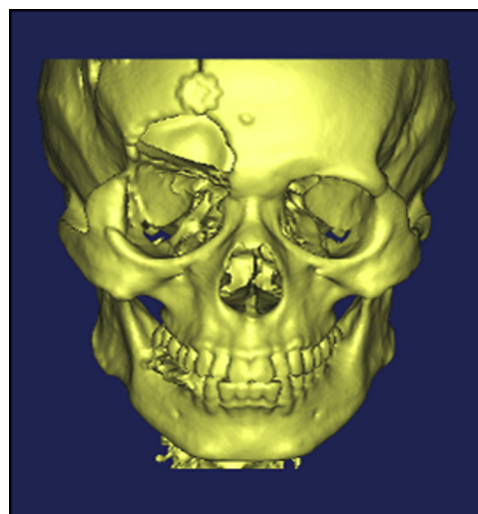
Preliminary 3D model of the maxillofacial bones built by the Mimics software after the CT scan.
